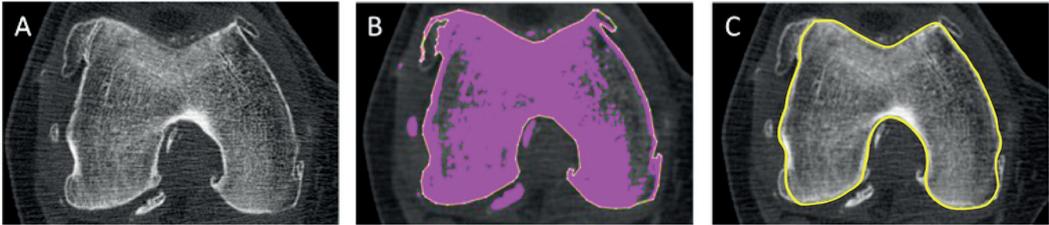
Example segmentation from 1 CT slice. (A) Axial CT slice; (B) thresholding of bone (pink); (C) final semi-automatic segmentation of this slice (yellow line), excluding osteophytes.
